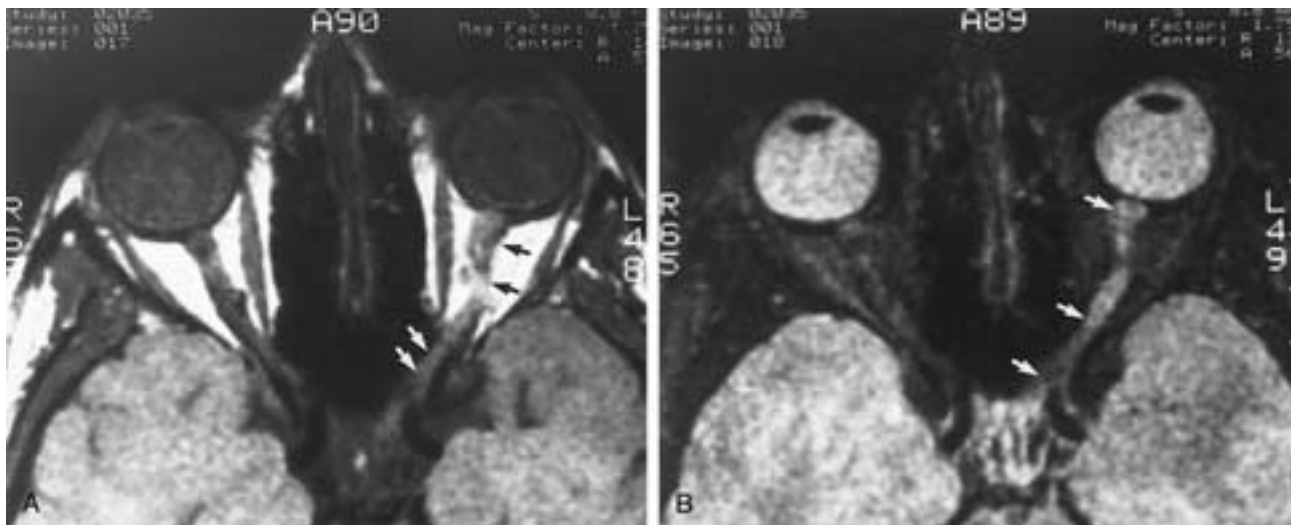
Optic neuritis. Axial PW (A) and T2-weighted (B) MR images show enlargement of the left entire optic nerve (*arrows*) in this 14-year-old girl with left optic neuritis.
